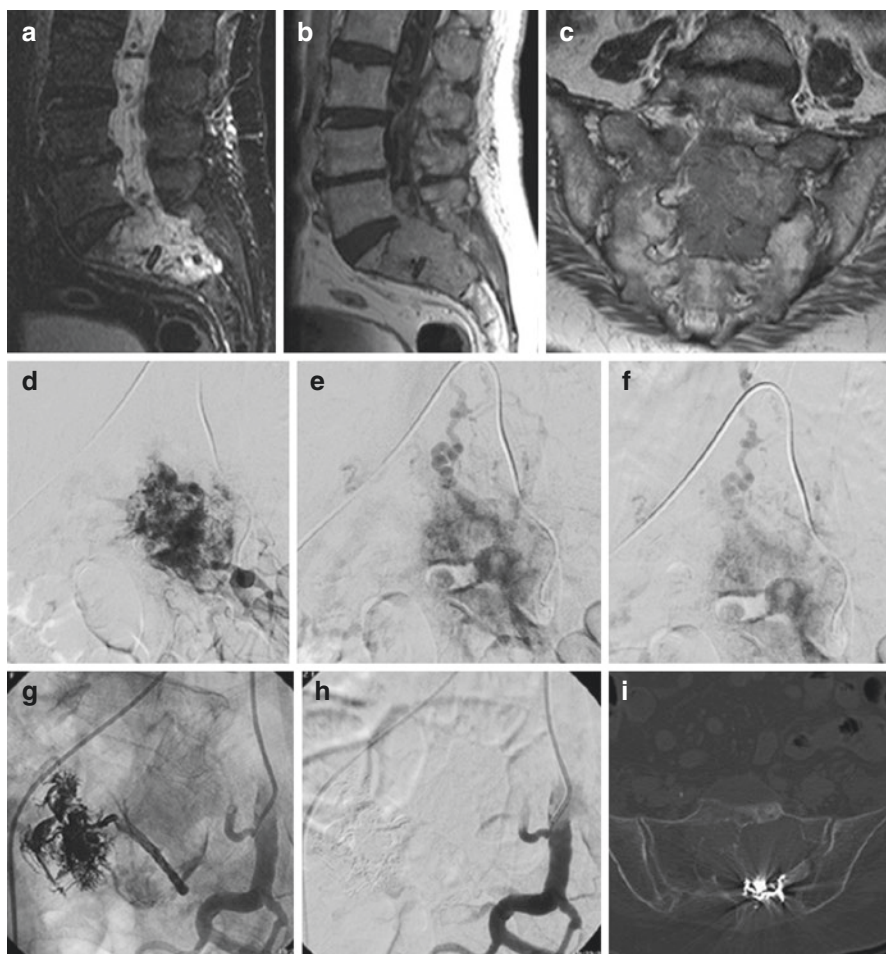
Sixty-year-old patient presenting with progressive paraplegia, bilateral limb numbness, and back pain. MR images (a, b, c) reveal a huge mass of the sacrum with posterior extension to spinal canal and sacral foraminae. A-P angiographic runs (d, e, f) show high vascularization of the lesion with drainage into a vein inside the spinal canal. Patient undergoes a preoperative embolization (g, h) of the lesion with Onyx and with PVA particles with reduction of blood supply of the lesion. Non-enhanced CT (i) shows the results of the endovascular procedure
